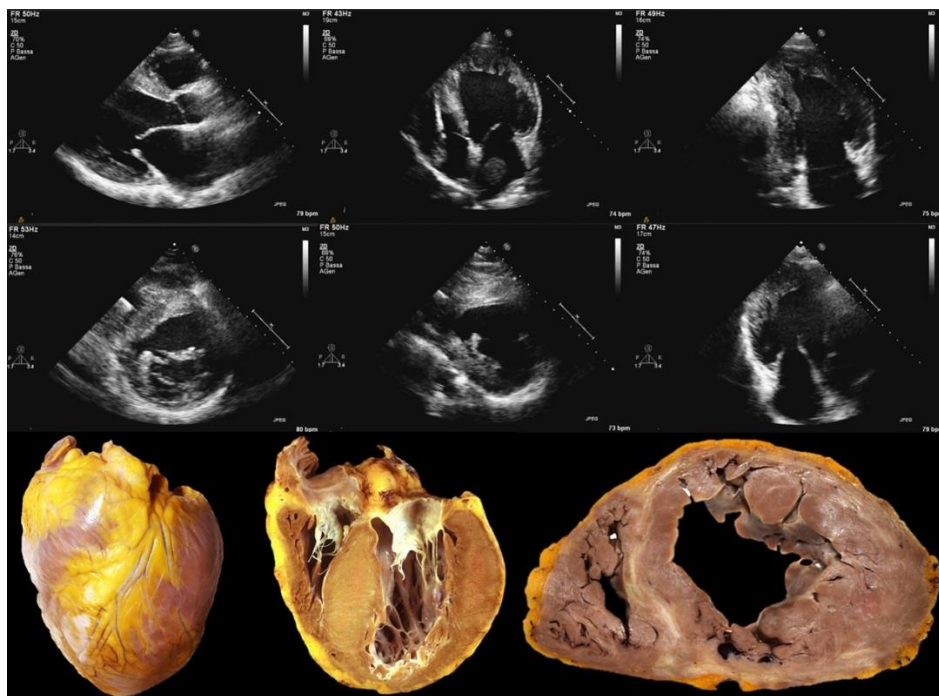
Echocardiographic and Pathological characteristics of End-Stage HCM (Dilated-Hypokinetic evolution). ES-HCM is characterized by a dilated and hypokinetic LV with thinned or normal left ventricular walls. Echocardiographic images show (in this case) a left atrial thrombus. Pathological images show fibrosis that is the white line inside myocardium.
